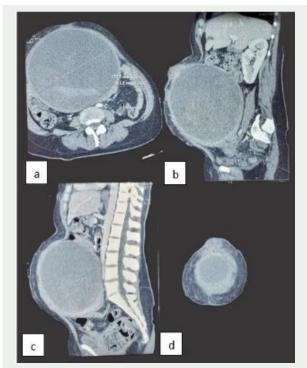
A 30-cm uterine fibroid complicated with aseptic necrobiosis and skin fistulation is shown by a CT scan of the abdominal cavity and pelvis.
